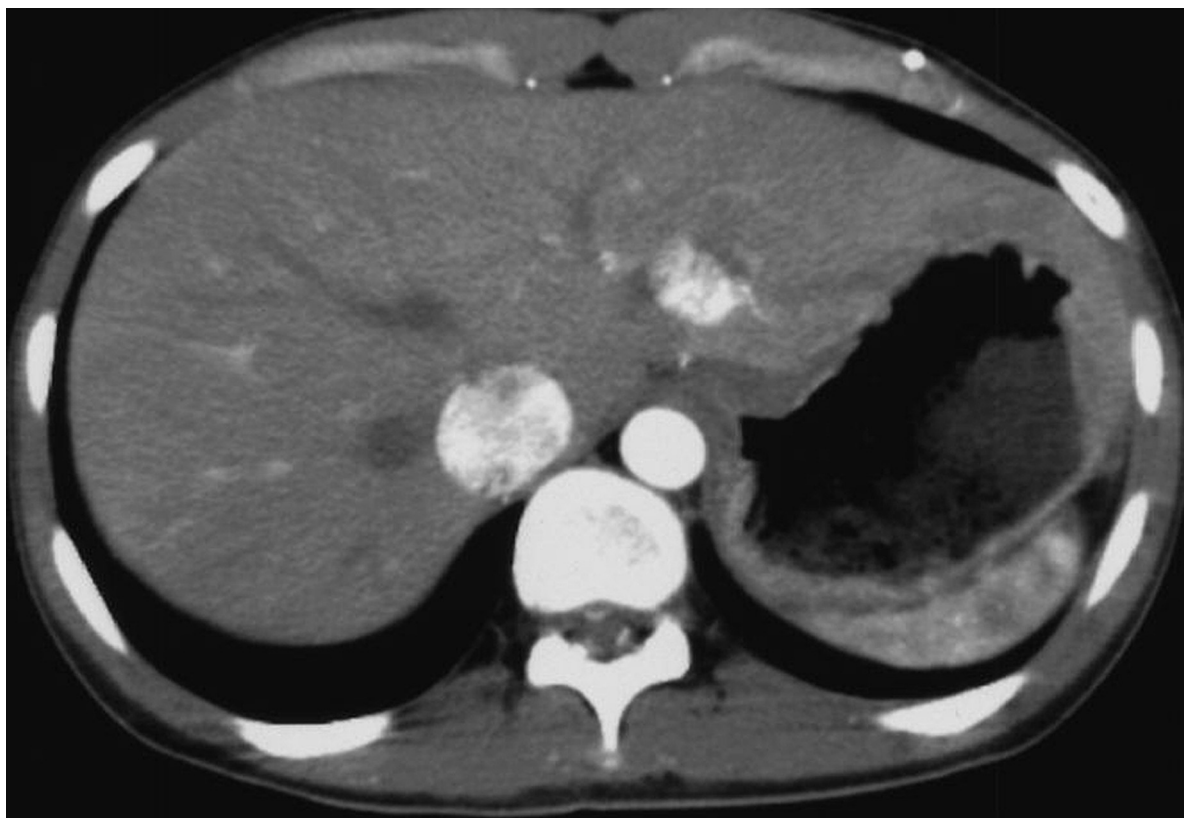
Abdominal computed tomography with contrast administration demonstrated hemangioma in left liver lobe.
